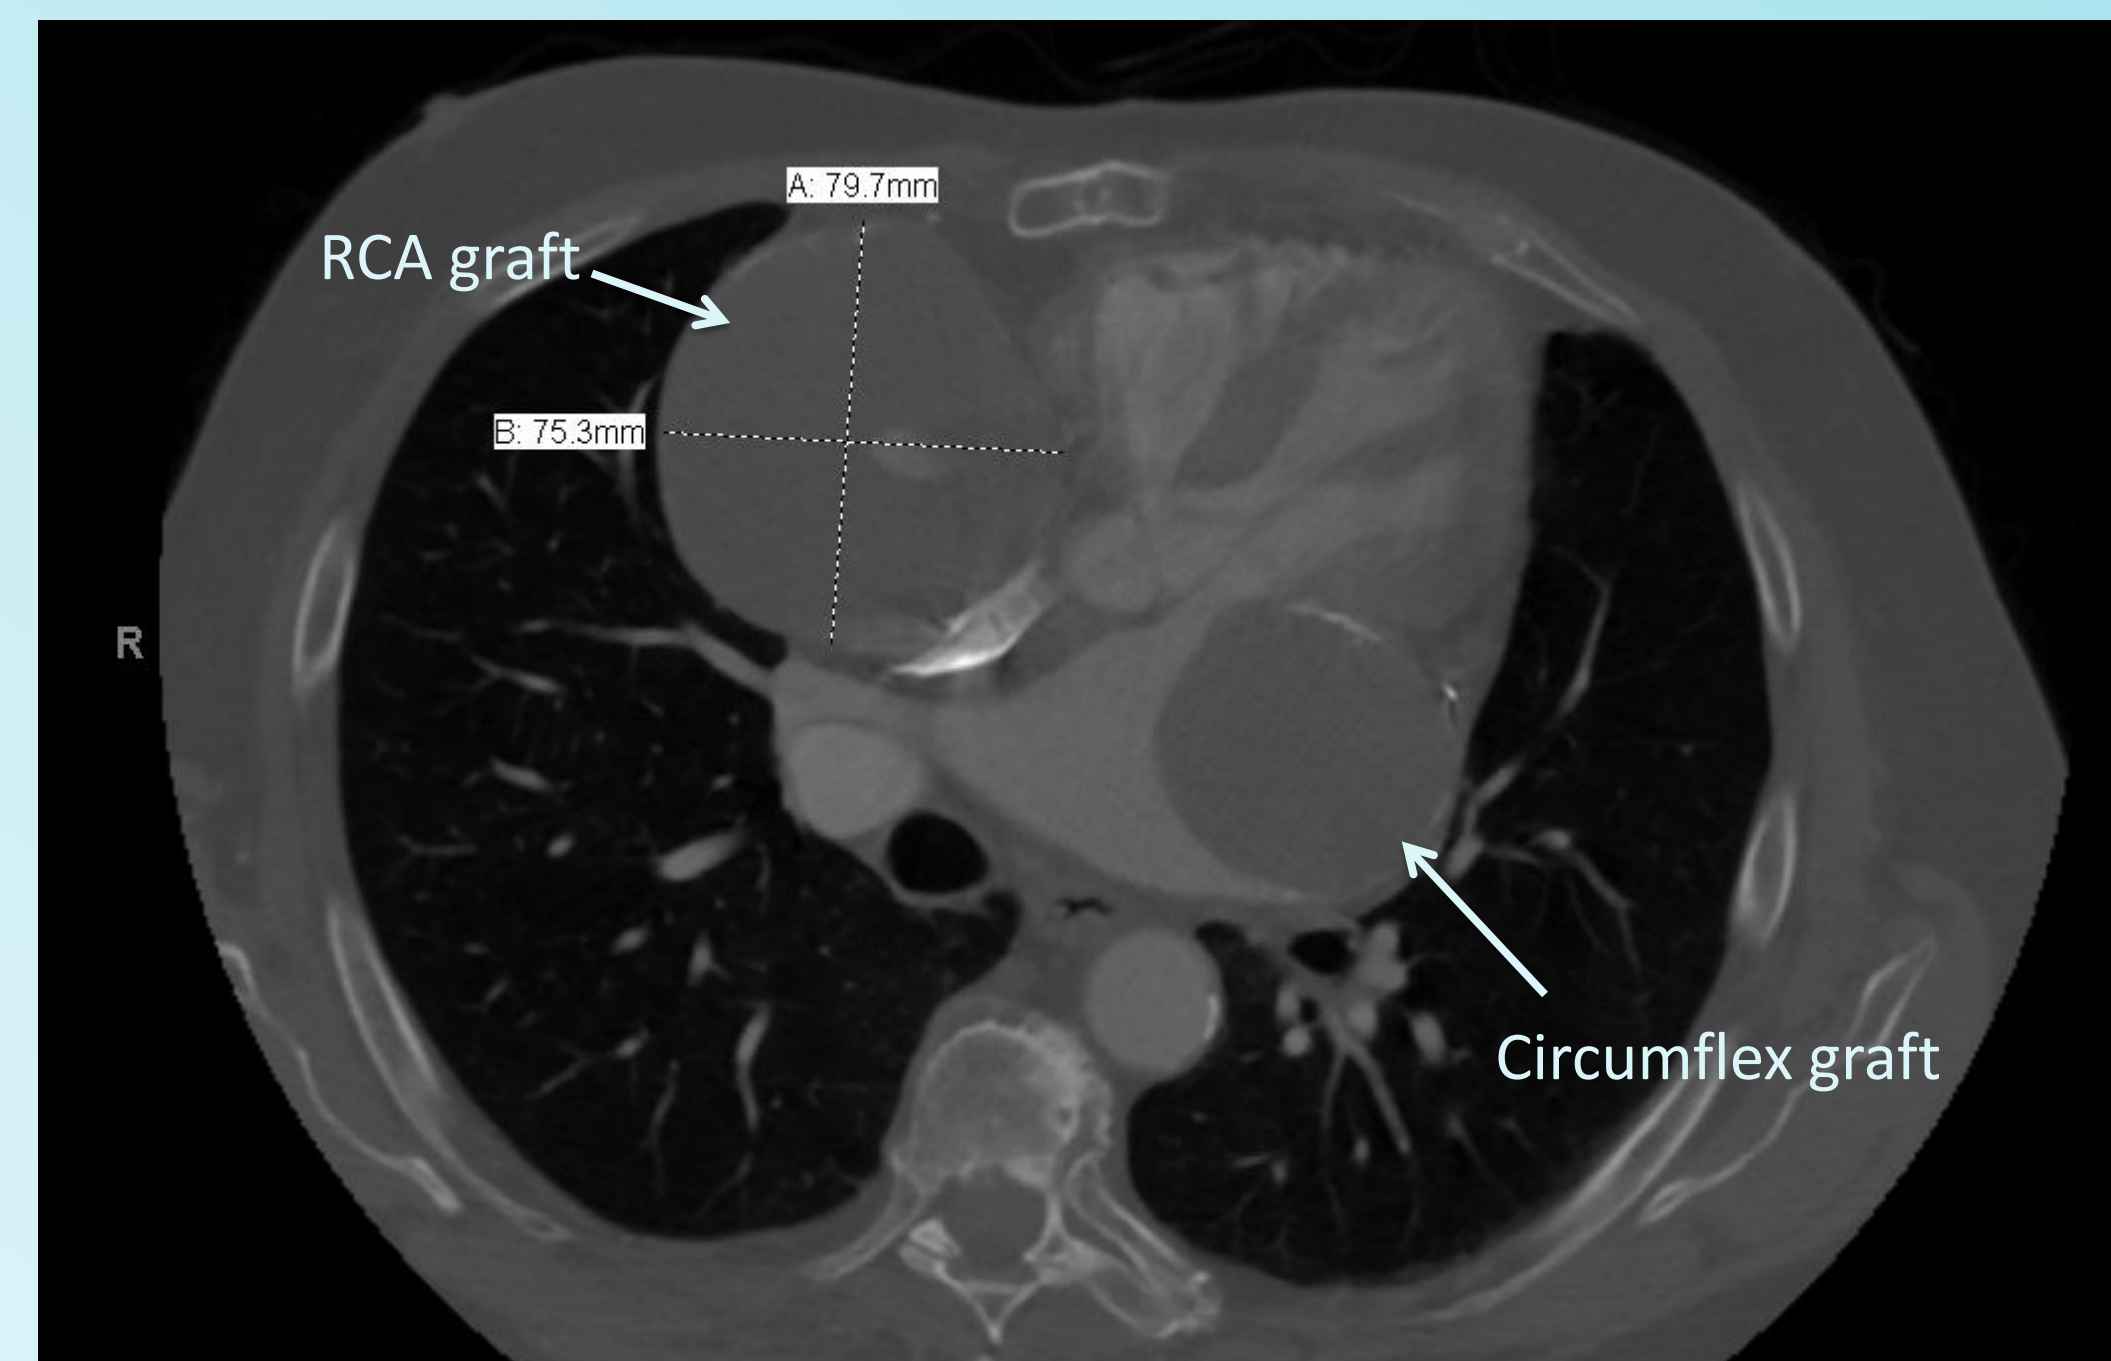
Patient CT scan prior to surgery showing the 8 cm RCA graft and 5 cm circumflex graft aneurysms
